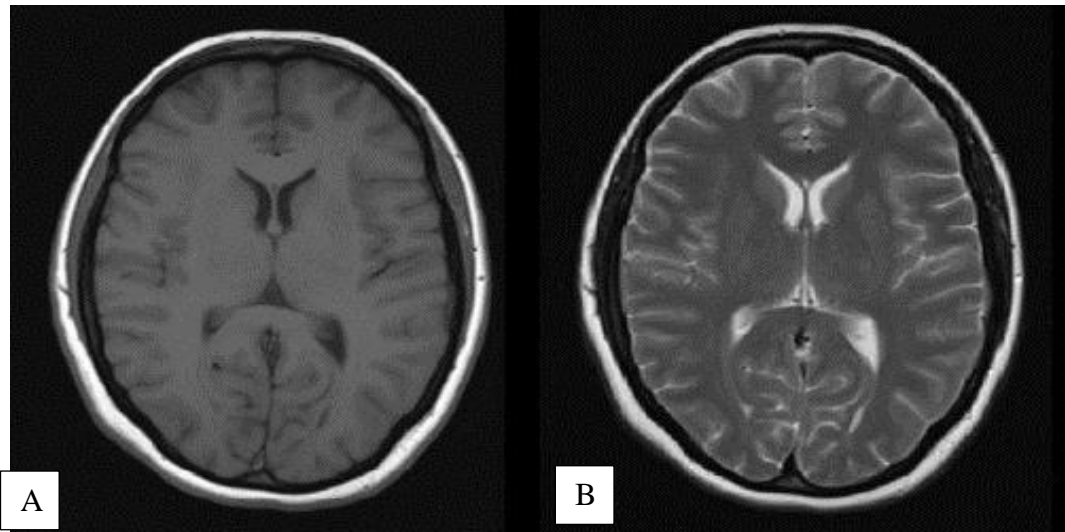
Typical A) FSE T_1 weighted image and B) FSE T_2 weighted images of an adult's head in a 1.5 T MRI scanner [198].
